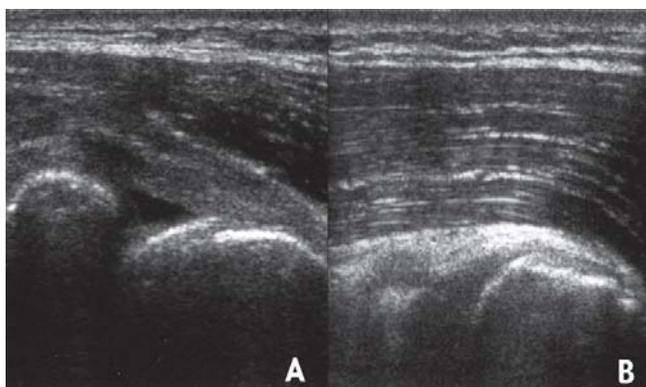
Preoperative sonography of lateral epicondylitis reveals hypochoic defect (A) and postoperative finding shows healing with uniformly arranged fibres (B).
